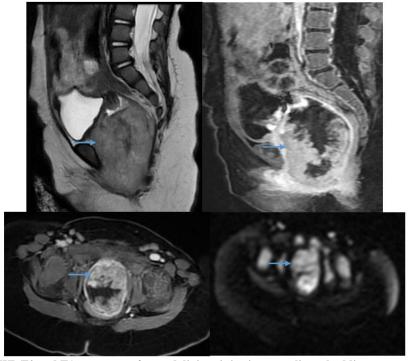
Pelvic MRI in DWI, T2 and T1 sequences after gadolinium injection revealing a budding tumor mass filling the vaginal cavity, consistent with a vaginal germ cell tumor
